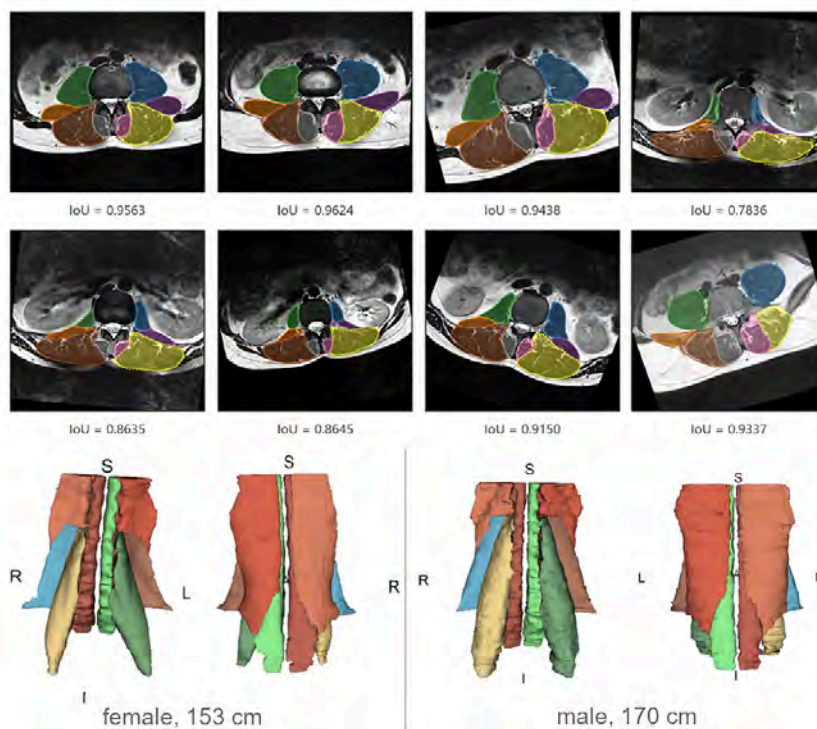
Figure caption. Exemplary segmentations performed on axial T2-weighted slices of the lumbar spine showing the relative Jaccard index ("IoU") (top). Exemplary three-dimensional reconstructions of the paravertebral muscles of two healthy volunteers (bottom).
